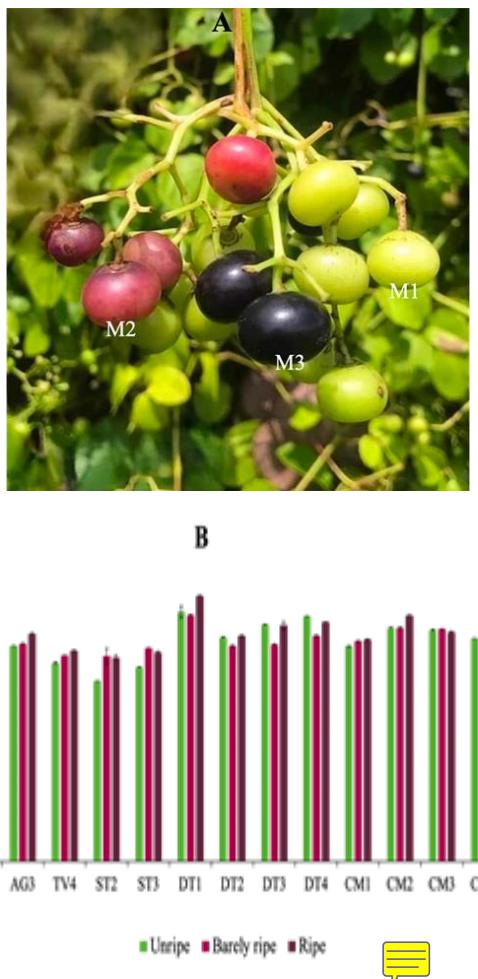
The effect of the ripeness stage on polyphenol content of CT berries. A: The picture of color changes in CT berries during the ripening stage: full-green (M1), purple (M2), and dark purple (M3).
